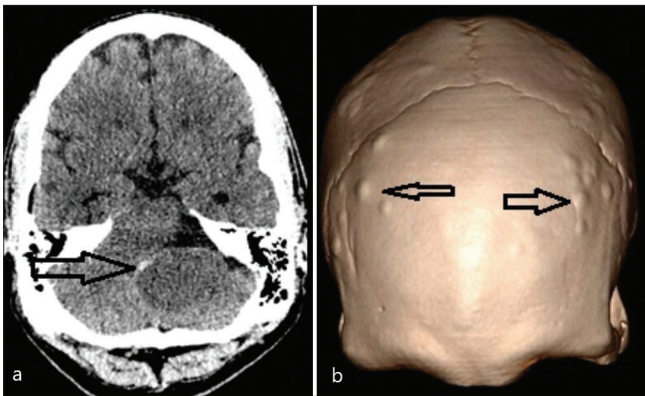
(a) Computed tomography (CT) scan showing marginal calcifications (arrow). (b) 3D reconstruction of the same scan shows multiple craniofacial osteomas (arrows).
